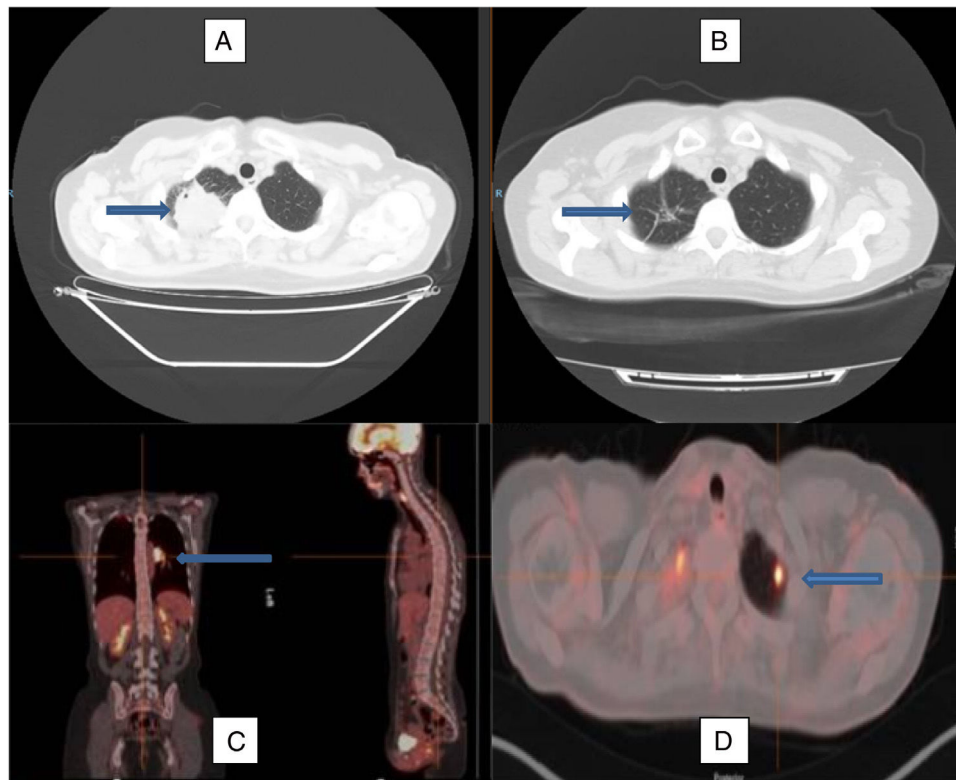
Computed axial tomography image at diagnosis (A) and after treatment with corticosteroids (B), showing remission of the lesion in the right upper lobe, with some remnants of residual fibrous tracts (arrows). PET-CT image with enhanced uptake in the left pulmonary hilum (C) and in the left upper lobe (D), marked by arrows, reflecting the multilobar involvement of this case.
